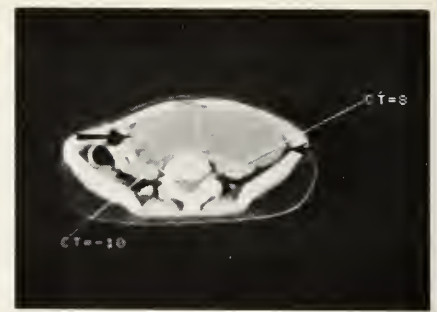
Left hydroureter within the pelvis on CT scan.
